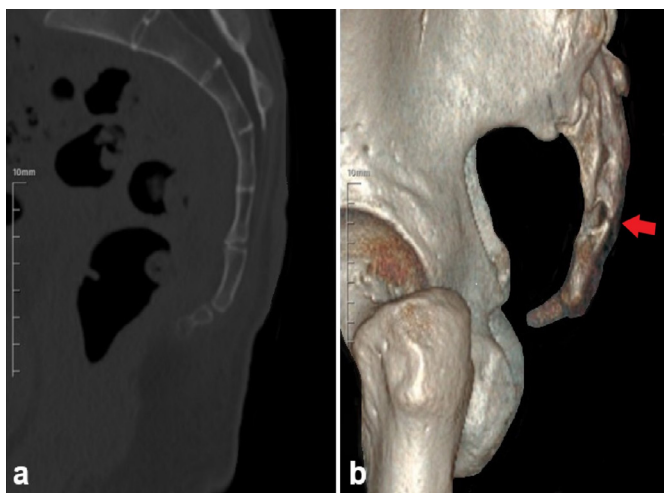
Sagittal bone window reformat computed tomography fracture of first coccygeal segment (a), 3-dimensional computed tomography fracture of first coccygeal segment (red arrow) (b)
